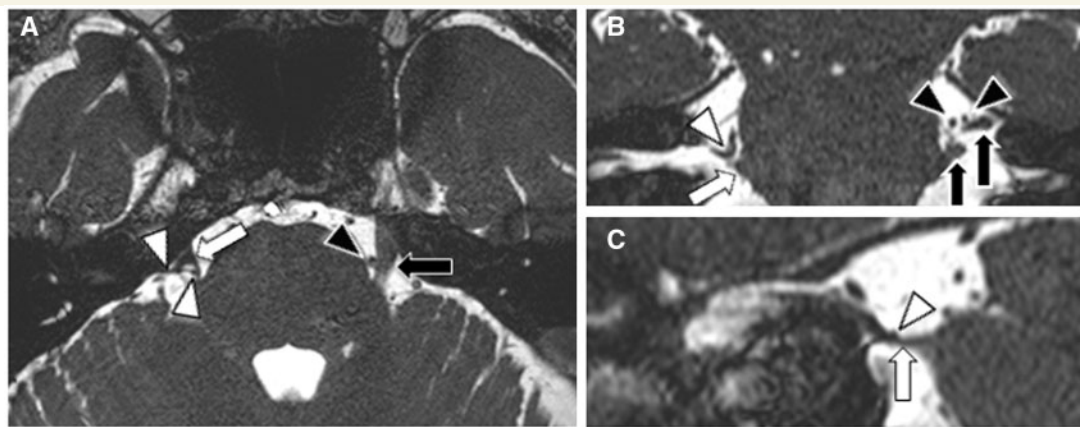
Neurovascular contact with atrophy. MRI balanced fast field echo with axial (A), coronal (B) and sagittal (C) planes of the posterior fossa showing an atrophic right trigeminal nerve (white arrows) caused by a loop of the right superior cerebellar artery (white arrowheads). Left trigeminal nerve has a simple neurovascular contact (black arrows) with the left superior cerebellar artery (black arrowheads). Patient suffers from right-sided trigeminal neuralgia.
